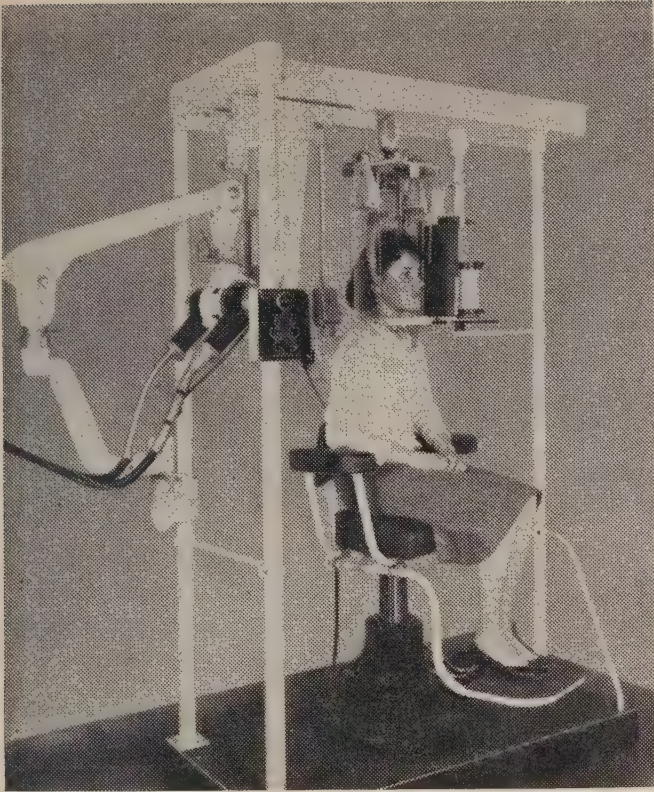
Rotagraph. (Blackman, Sydney and Poyton, H.G. A manual of dental and oral radiography. Bristol, Wright, 1963.)
